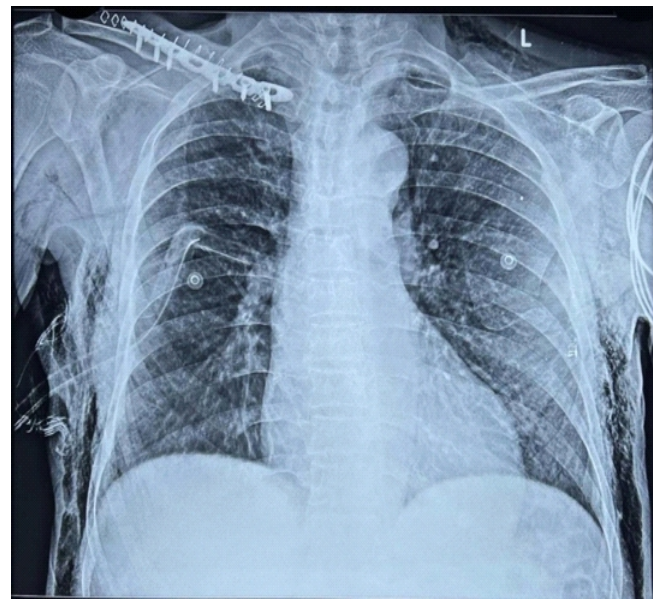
Post-operative chest radiograph following clavicle fixation with intercostal drainage (ICD) tube in situ.
